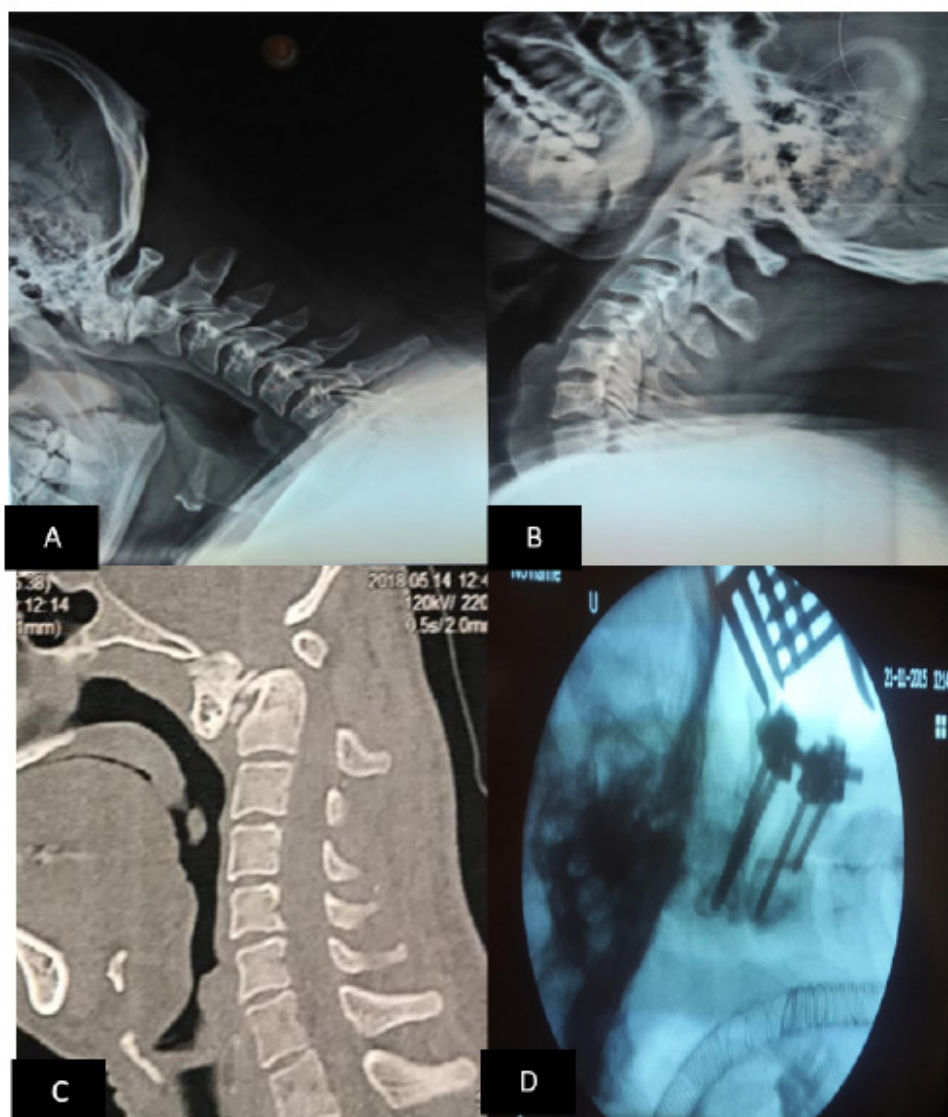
(A,B): Preoperative dynamic X-ray of fifty-four year old male patient with atlantoaxial subluxation. (C): Preoperative sagittal CT of cervical spine proving atlantoaxial subluxation. (D): Intraoperative fluoroscopic image with proper reduction of atlantoaxial subluxation using bilateral C1 lateral mass screws fixation and C2 pedicle screw on left side and right pars screw.
